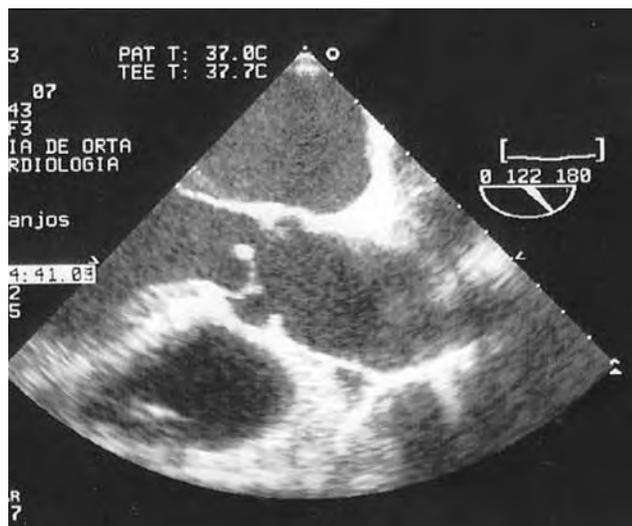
Image of transesophageal ultrasound highlighting compatible echogenic images with vegetation, adhering to the ventricular face of the left coronary leaflet and non-coronary of the aortic valve.
